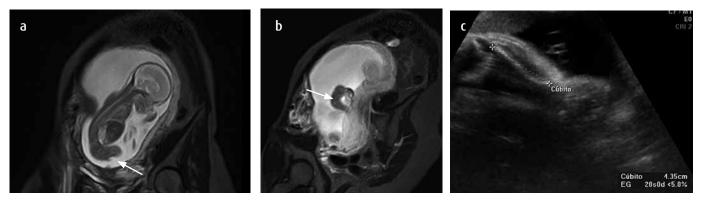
MRI a) with coronal T2 information; b) Sagittal STIR. Patient with a history of second-trimester ultrasound with suspected achondroplasia. Fetal MRI at 22.2 weeks: Femur shortening a) and humerus b) (arrows) bilateral. Thoracoabdominal disproportion. c) Ultrasound of obstetric detail in the third trimester, in which the length of long bones remains below the expected percentile, in relation to achondroplasia.
